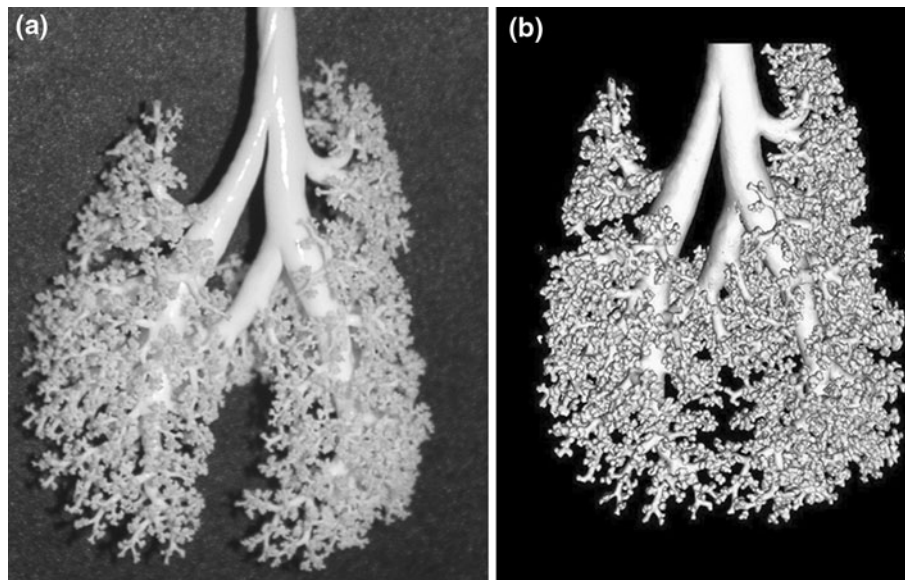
Example of (a) lung airway cast and (b) 3D reconstruction of CT image from the cast.
